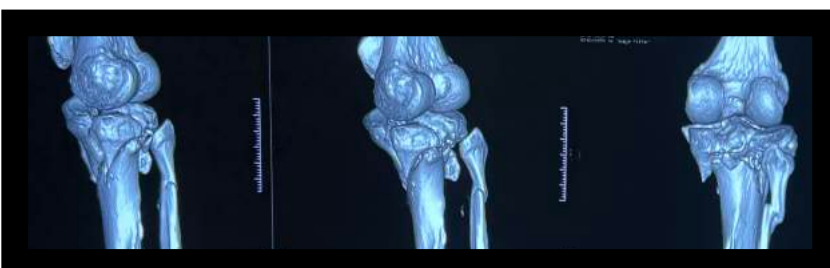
3D CT scan showing the complexity of the problem
